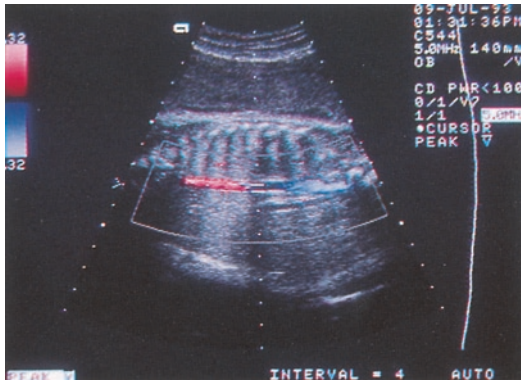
Recording of fetal aortic velocities with a duplex ultrasound system including a sector scanner and a pulsed and color Doppler mode. A good image of the fetal descending aorta is obtained. The insonation angle for Doppler ultrasound is close to 90°, however, which gives no or low amplitude shift signals in the spectral Doppler mode and no color in the color Doppler mode
